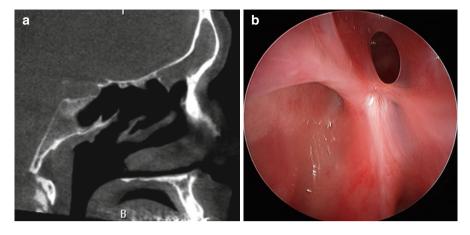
Iatrogenic frontal sinus disease secondary to scarring between the uncinate process and bulla ethmoidalis. (a) Sagittal CT scan demonstrating frontal sinus opacification and (b) endoscopic view of mucosal adhesion secondary to scarring between the uncinate process and bulla ethmoidalis
